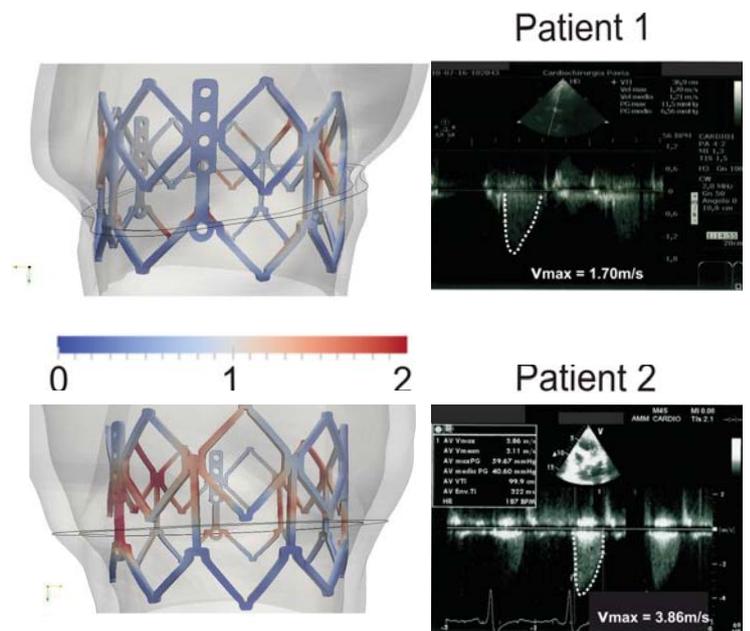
Evaluation of the degree of apposition between the prosthesis stent and the patient-specific aortic root anatomy: a contour plot of the distance [mm] between the aortic wall and the prosthetic stent is represented. Correspondent postoperative ultrasound images for the two considered patients are shown highlighting a greater retrograde blood flow for Patient-2 than for Patient-1.
